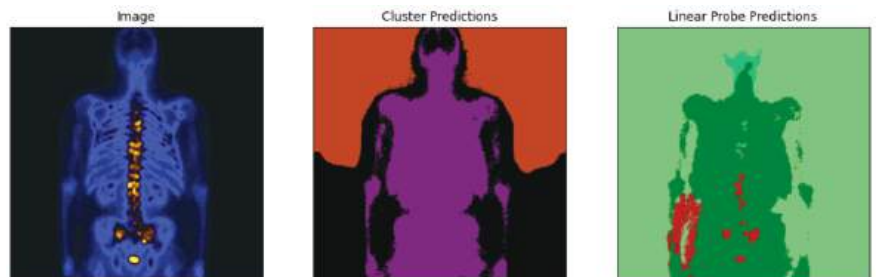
The initial scintigraphy image and incorrect STEGO outputs for a patient with metastasis on the spine.
